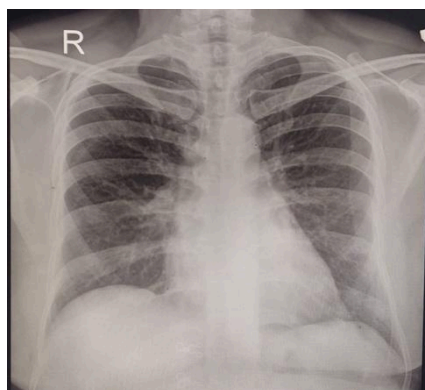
Chest X-ray shows increased bronchovascular markings, air bronchogram within normal limits, and normal heart size
